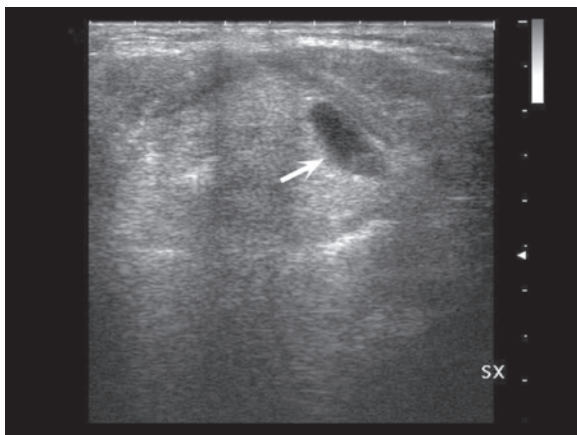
c Recurrence of cervical cancer. US study (a) shows a heterogeneous hypoechoic nodulation in the left iliac fossa (*long arrow*) adjacent to the descending colon (*short arrow*) confirmed by CT (b) as well as PET and US-guided biopsy. The finding of this single lesion in an unusual location was possible because of a thorough abdominal-pelvic US study, whereas the finding is immediately recognizable on CT. Confirmation with FNAC (c, *arrow*)
